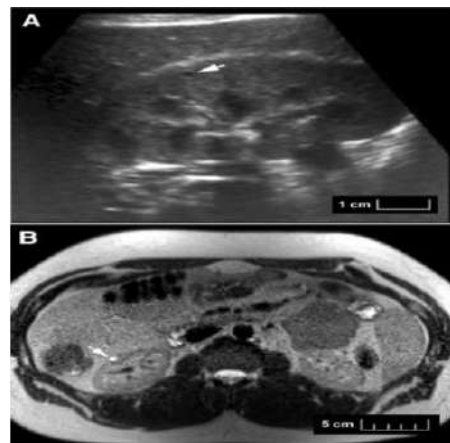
shows a small cortical renal cyst (approximately 2.5 mm) denoted by arrows in A (HR US) and B (MRI) [1].
